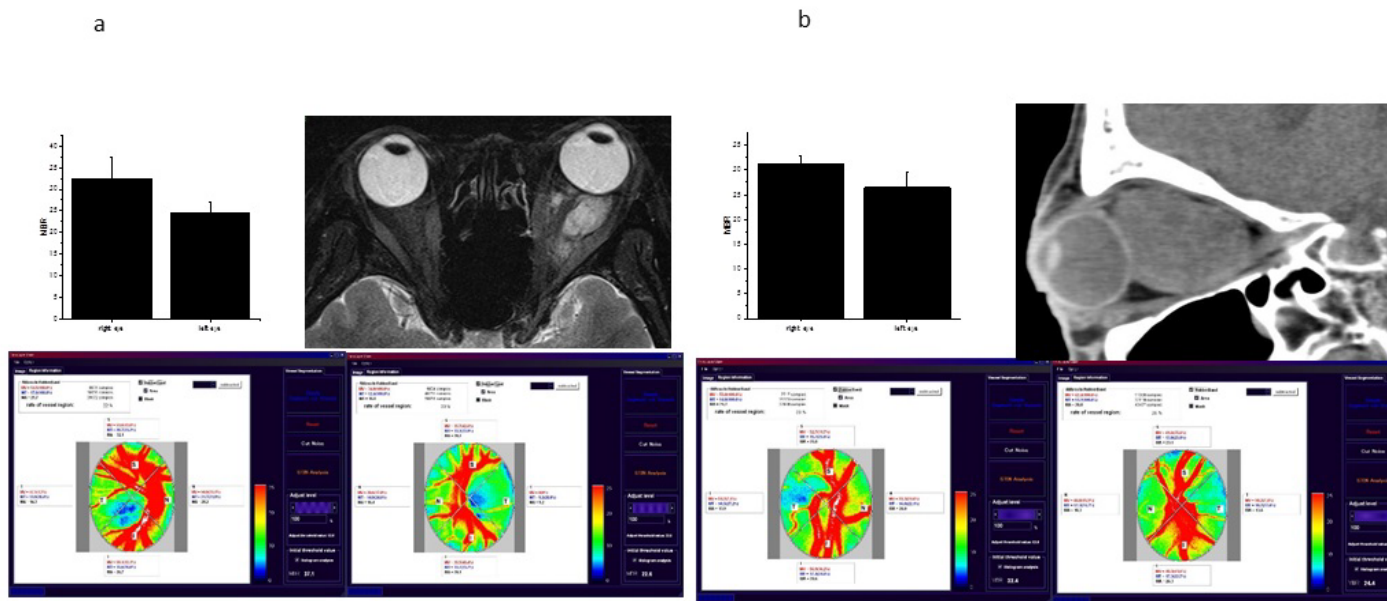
(a) Case 5: Mean MBR: right eye; 32.4 ± 4.86 , left eye; 24.63 ± 2.48 (top left). Orbital MRI (top right). Representative LSFG of the right (bottom left), and left eye (bottom right). (b) Case 6: Mean MBR: right eye; 31.3 ± 1.55 , left eye; 26.4 ± 3.18 (top left). Orbital MRI (top right). Representative LSFG of the right (bottom left), and left eye (bottom right).
